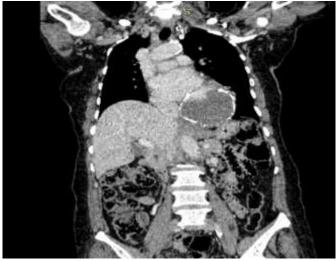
Thoraco-abdominal-pelvic CT scan (frontal view) showing the mass bulging out in the left cavities.
